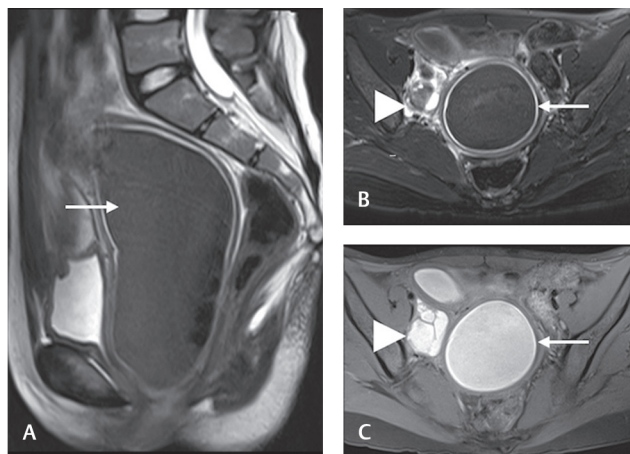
(A–C) T2W sag (A), FS T2W (B), and T1W (C) axial images showing a distended vagina filled with hemorrhage due to outflow obstruction (arrow) along with right endometrioma (arrowhead in B and C). FS, fat-suppressed; T1W, T1-weighted; T2W, T2-weighted.
